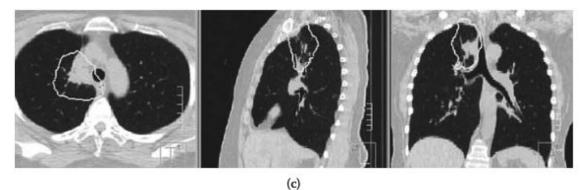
Reduction of lung tumor gross tumor volume (GTV). Computed tomography images were acquired (a) pre-RT with initial GTV (b) at 30 Gy, with initial contour displayed, showing 42% volume reduction, and (c) at 50 Gy, with initial contour displayed, showing 71% volume reduction. (Reprinted from Fox, J., et al. 2009. *Int J Radiat Oncol Biol Phys* 74(2):341–8. With permission.)
